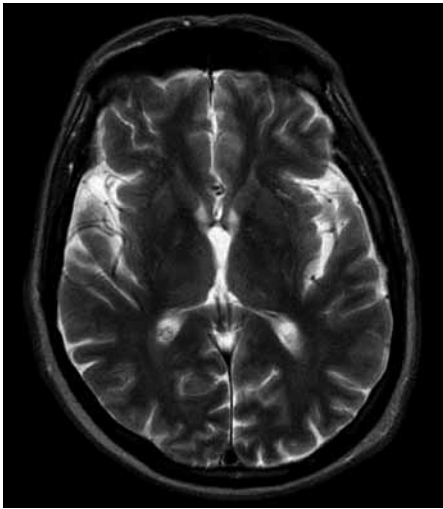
T2-weighted magnetic resonance imaging of basal ganglia showing normal appearance.
